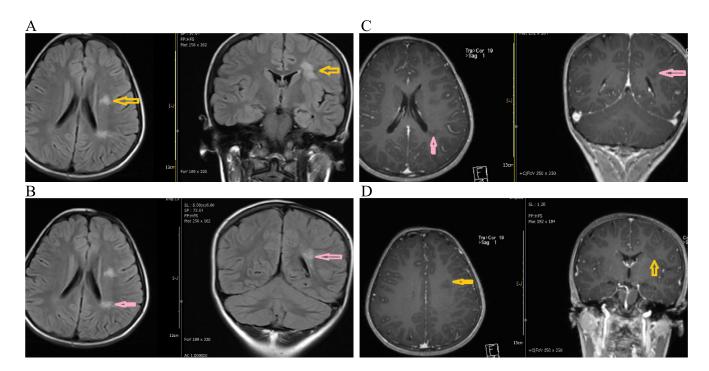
(A) Left: axial T2 fluid attenuation inversion recovery (FLAIR) image demonstrates frontal periventricular subcortical white matter lesion (yellow arrow). Right: coronal T2 FLAIR image demonstrates periventricular subcortical white matter lesion (yellow arrow). (B) Left: axial T2 FLAIR image demonstrates parietal periatrial subcortical white matter lesion (pink arrow). Right: coronal T2 FLAIR image demonstrates parietal periatrial subcortical white matter lesion (pink arrow). Right: coronal T2 FLAIR image demonstrates parietal periatrial subcortical white matter lesion (pink arrow). Right: coronal T2 FLAIR image demonstrates parietal periatrial subcortical white matter lesion (pink arrow). (C and D) Left upper, right upper: axial and coronal postcontrast T1 weighted multiplanar reformat imaging, respectively. Frontal periventricular subcortical white matter lesion shows mild enhancement (yellow arrow). Left lower, right lower: axial and coronal postcontrast T1 weighted, respectively. Parietal periatrial subcortical white matter lesion shows mild enhancement (pink arrow).
